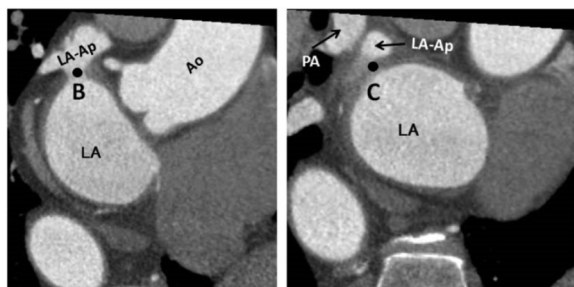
Determination of points B and C on frontal section of multi-detector CT
